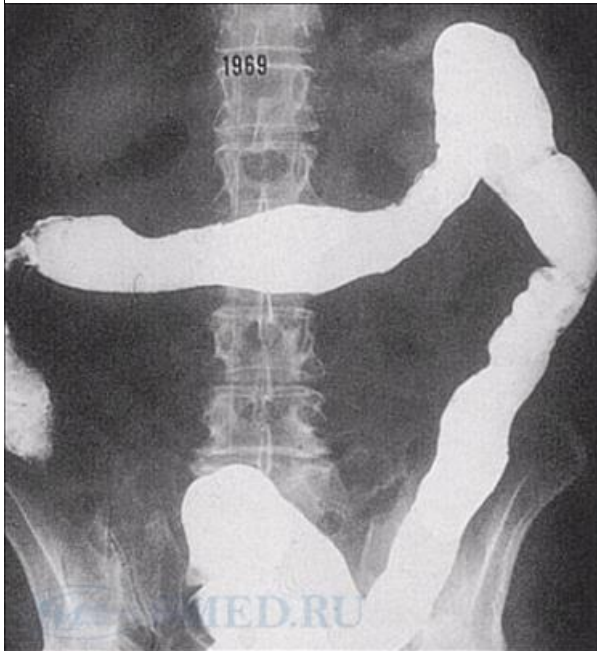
On radiographs represented sections of the large intestine. Contours are smoothed, disappeared haustration. Intestine narrowed, rigid. This picture of severe ulcerative colitis.
